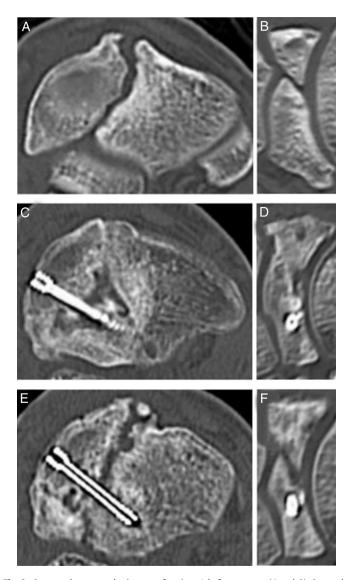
Computed tomography images of patient 1 before surgery (*A* and *B*), 3 months after surgery (*C* and *D*), and 8 months after surgery (*E* and *F*). In the preoperative images, the 2 portions of the navicular appeared wedge-shaped, with narrow tapering margins. The images taken 3 months after surgery appeared to show bony union of the fragments. However, they had separated at 8 months after surgery.
